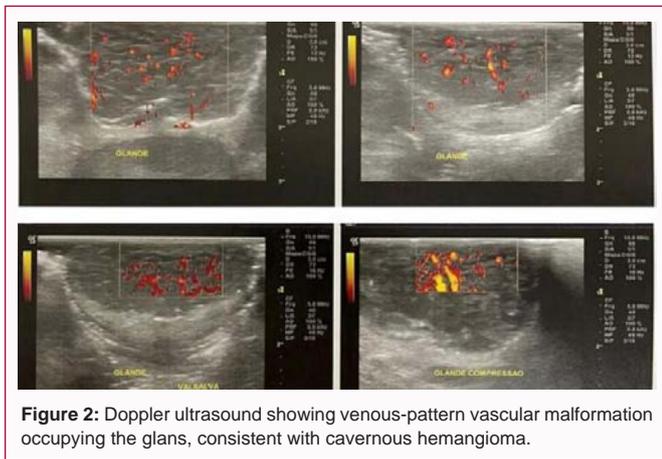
Doppler ultrasound showing venous-pattern vascular malformation occupying the glans, consistent with cavernous hemangioma.
